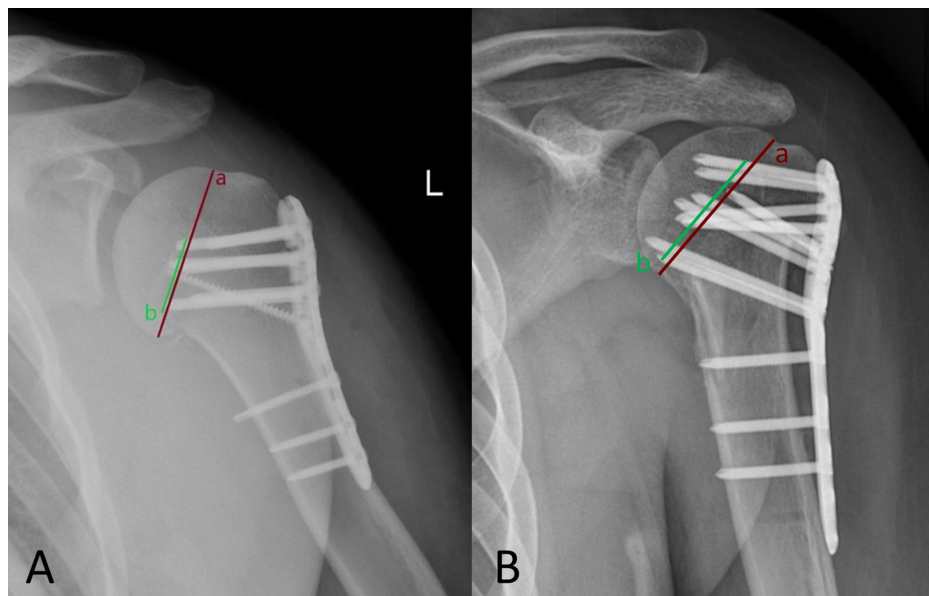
Anteroposterior radiographic comparison of variable angle and fixed angle proximal humerus plate constructs. (A) Variable angle construct and (B) fixed angle construct. Line a represents the anatomical neck of the humerus, and line b represents the vertical distance between the most superior and most inferior proximal screws intersecting the anatomical neck. The ratio b/a defines the percentage of anatomical neck height covered by the proximal screws and was used to quantify coronal screw distribution.
